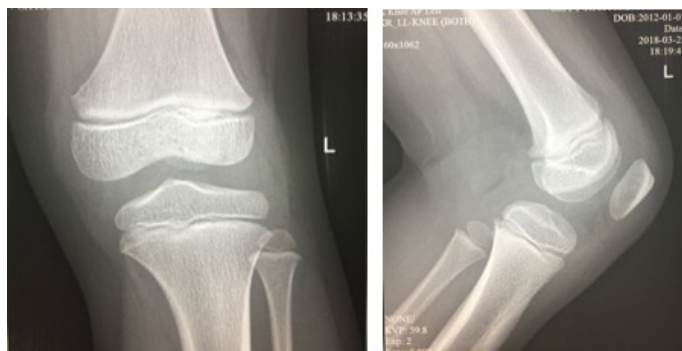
Left knee X-ray of the patient at day 1 of trauma. Posteroanterior view (left) and lateral view (right) showed normal x-ray
